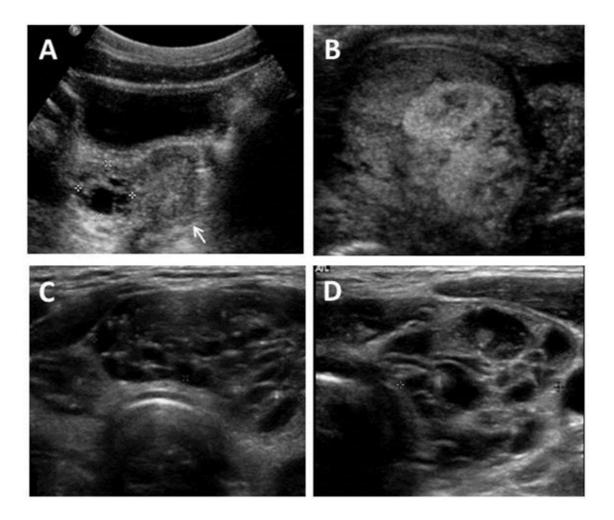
Ultrasonography findings of ovarian, testicular, and thyroid disease
